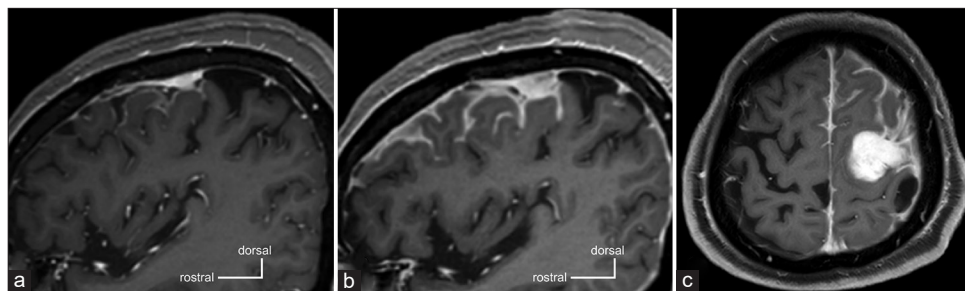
Magnetic resonance imaging on admission (a) and 1 month later (b and c). Gadolinium-enhanced T1-weighted sagittal image on admission shows leptomeningeal enhancement around the tumor (a), which is markedly enlarged 1 month later ([b], sagittal image; [c], axial image).
